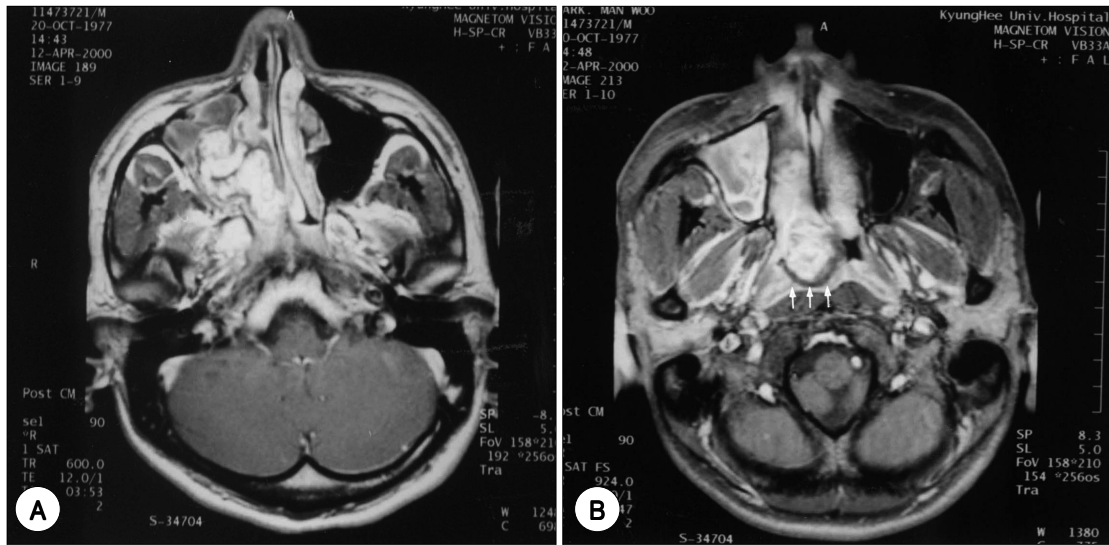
Gd-enhanced T1-weighted MRI scan shows high signal intensity of portion in the right maxillary sinus (A) and differently enhancing portion in the nasopharynx (arrow) (B).
